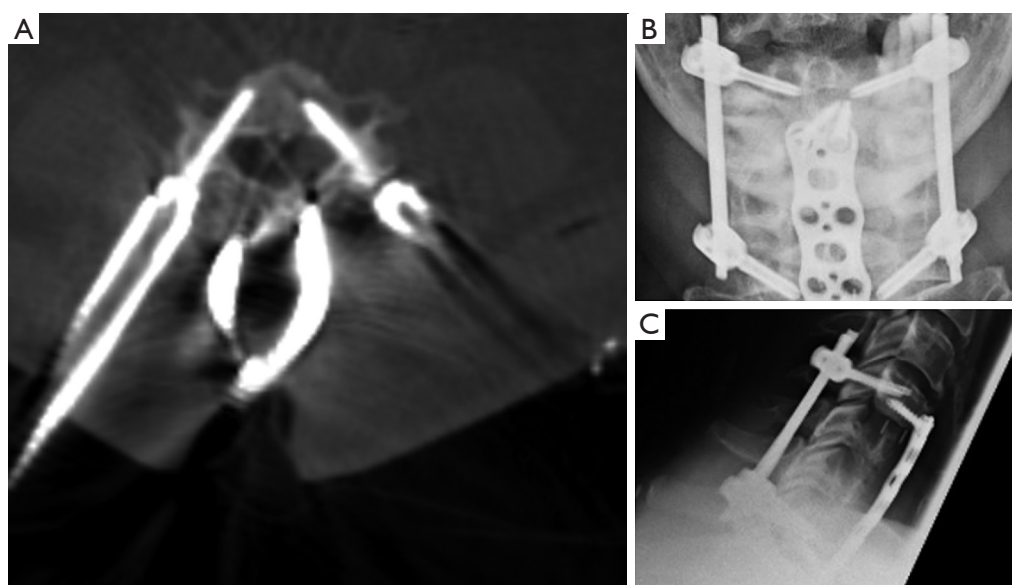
Examples of intra and postoperative radiographical assessment. (A) Accuracy of screw placement is usually assessed intraoperatively before rods are implanted. In this case at level C4. The reference was also attached to the spinous process of C4. (B,C) Are examples of postoperative radiograms of a patient that received percutaneous dorsal fixation due to minor bone quality following ventral 2-level corporectomy in a case of degenerative cervical myelopathy.
